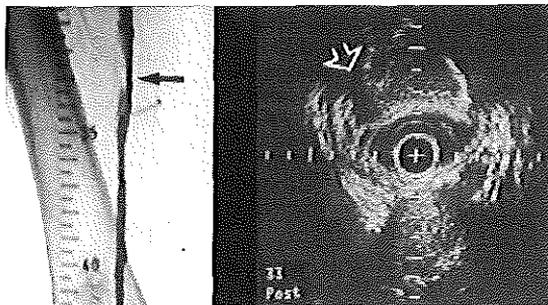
Angiographic and intravascular ultrasonographic cross section of superficial femoral artery after balloon angioplasty. At level 33 both techniques reveal dissection. Semiquantitative and quantitative analyses with respect to degree of stenosis were not possible echographically given inadequate ultrasound information seen beyond dissection (arrow). Plus sign indicates catheter; calibration, 1 mm.
